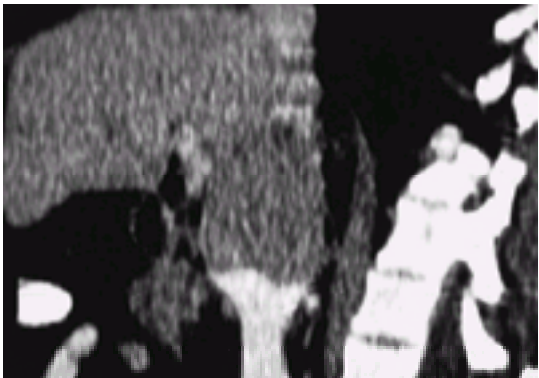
Renal cell carcinoma with extension into the inferior vena cava on MRI scan (saggital section).
